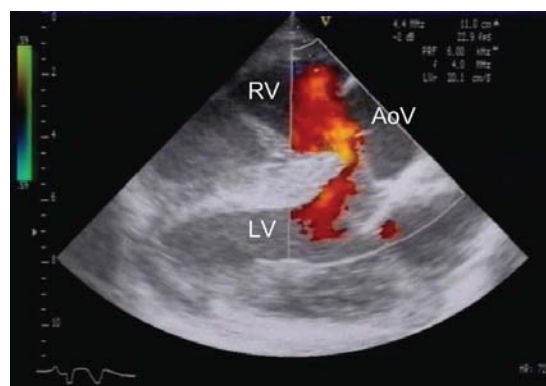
Right parasternal long axis-view. Diastolic left to right shunt (red) through the ventricular septal defect between the 2 heart chambers. LV = left ventricle; RV = right ventricle; AoV = aortic valve.
